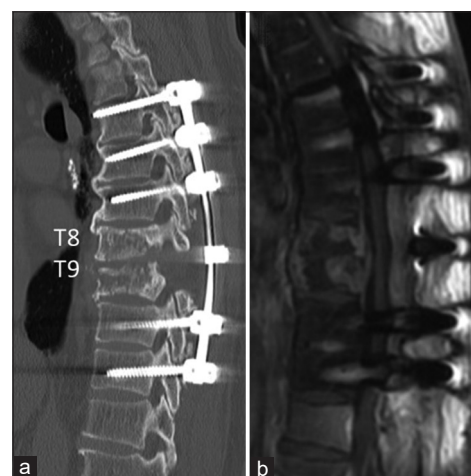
After the second surgery, postoperative follow-up images. Two months after the second surgery, postoperative images: (a) Sagittal computed tomography shows no further progression of kyphotic deformity. (b) T1-weighted contrast magnetic resonance imaging shows decreased size of the paravertebral abscess
